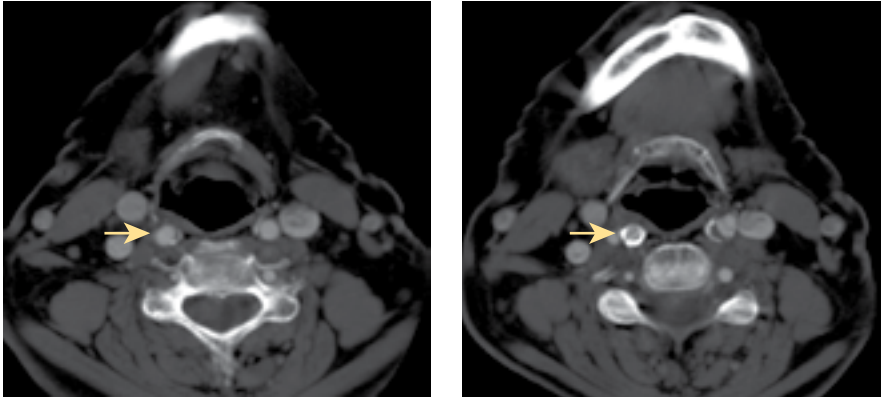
Thinly sliced images from a computed tomography (CT) scan through the carotid arteries are taken at the level of the plaque. On the left image there is no calcium seen in the artery wall (arrow). The right image shows dense white calcium surrounding most of the artery at this level (arrow).
